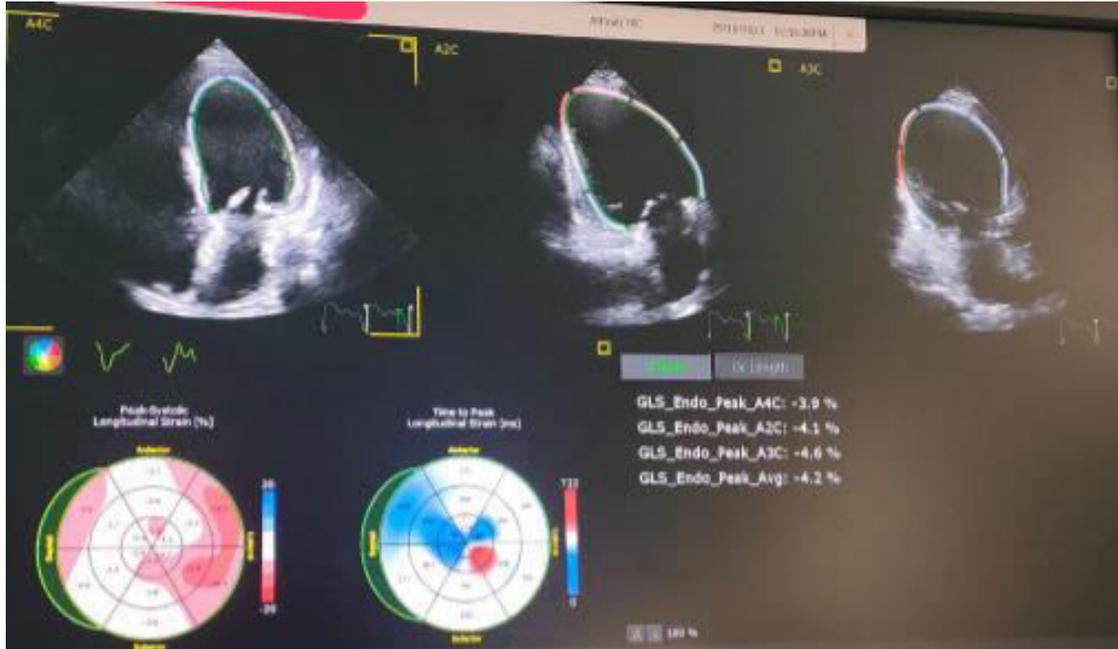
Pre management Global Longitudinal Strain of 2-dimensional speckle tracking echocardiography.
